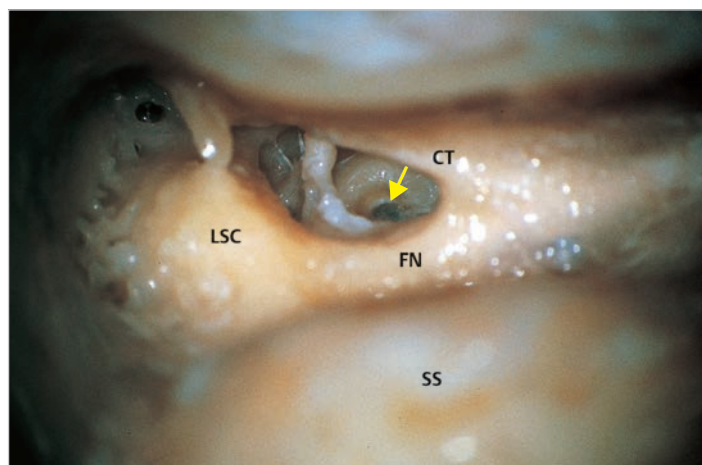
Posterior tympanotomy in a different bone is shown. The round window niche is seen through the posterior tympanotomy (arrow). CT, chorda tympani; FN, facial nerve; LSC, lateral semicircular canal; SS, sigmoid sinus.
